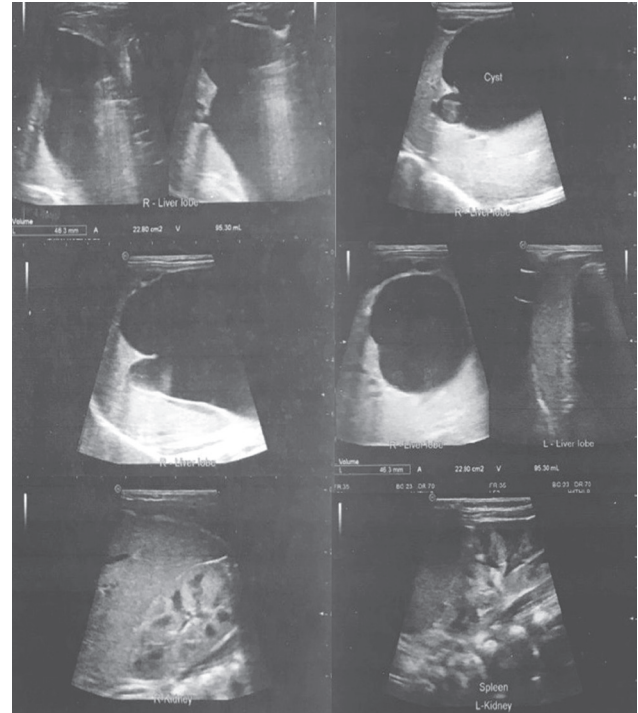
Abdominal ultrasound showed choledochal cyst type 1.
